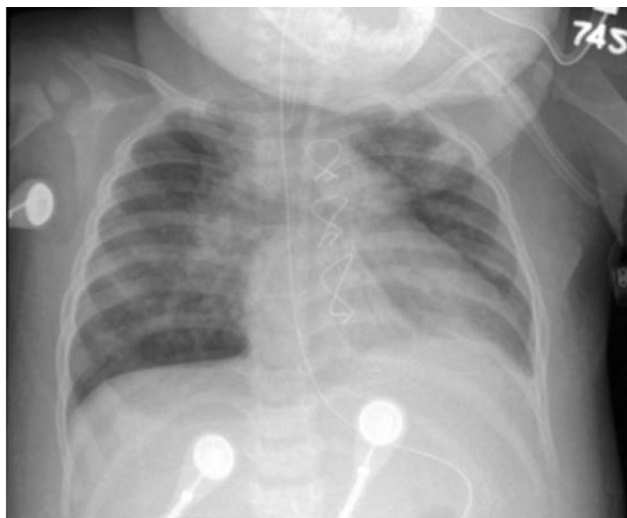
Chest radiograph on pediatric intensive care unit day 5 shows heterogeneous bilateral opacities.
